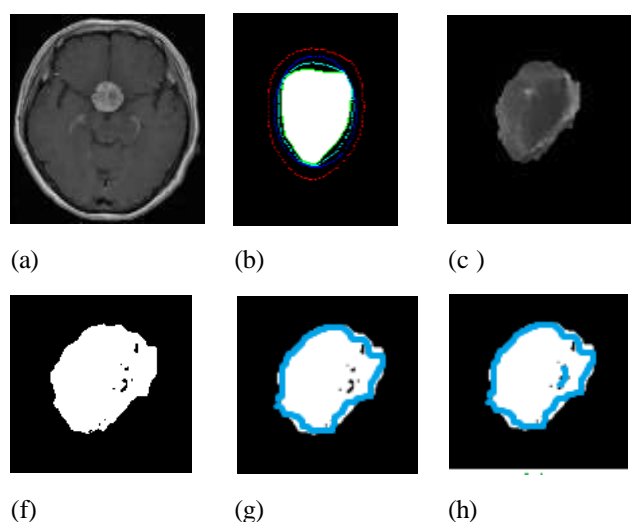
Tumor kind Glioblastoma Experimental effects (a) Input MRI Image (b) RCE device (c) CAS Output (d) FCM output (e) Region selection input (f) output for proposed segmentation
